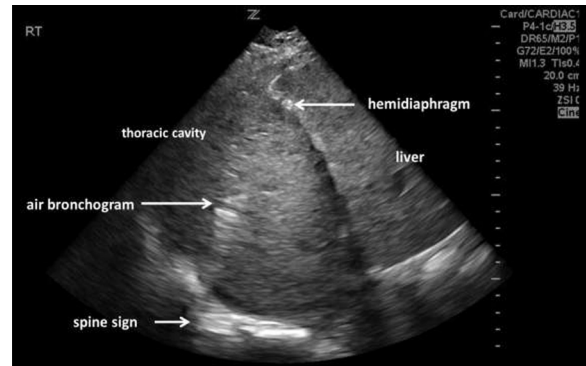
Point of care ultrasound of the right lung. Note the empyema compressing the liver and the spine sign seen in the deep area.
